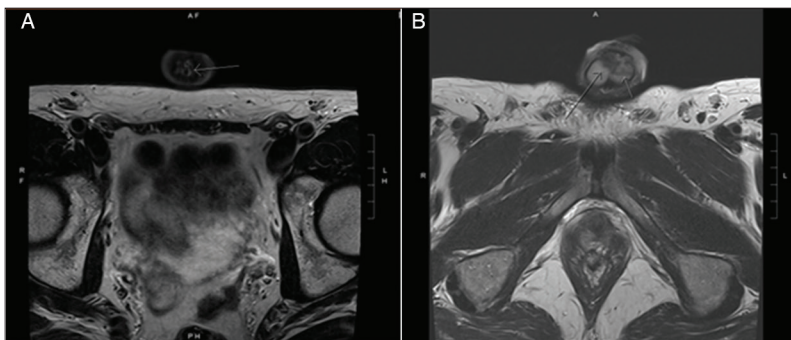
Results of magnetic resonance imaging of the penis.
